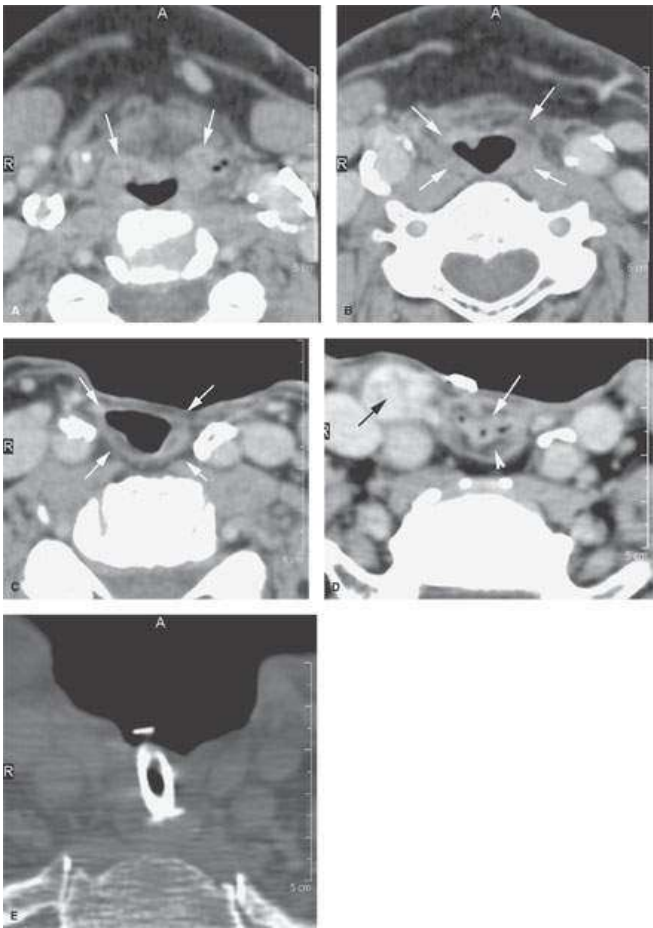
Contrast-enhanced computed tomography of a patient who had laryngectomy for laryngeal carcinoma and reconstruction of the pharynx by primarily closing the residual pharyngeal wall. This is the most common form of reconstruction of a neopharynx following laryngectomy. A–D: The margins of a normal-appearing neopharynx and relatively normal surrounding soft tissues are demonstrated by the arrows. In (D), the residual thyroid gland preserved for both thyroid and parathyroid function on the right side happens to contain a benign nodule (arrow). The neopharynx at that level has an appearance consistent
